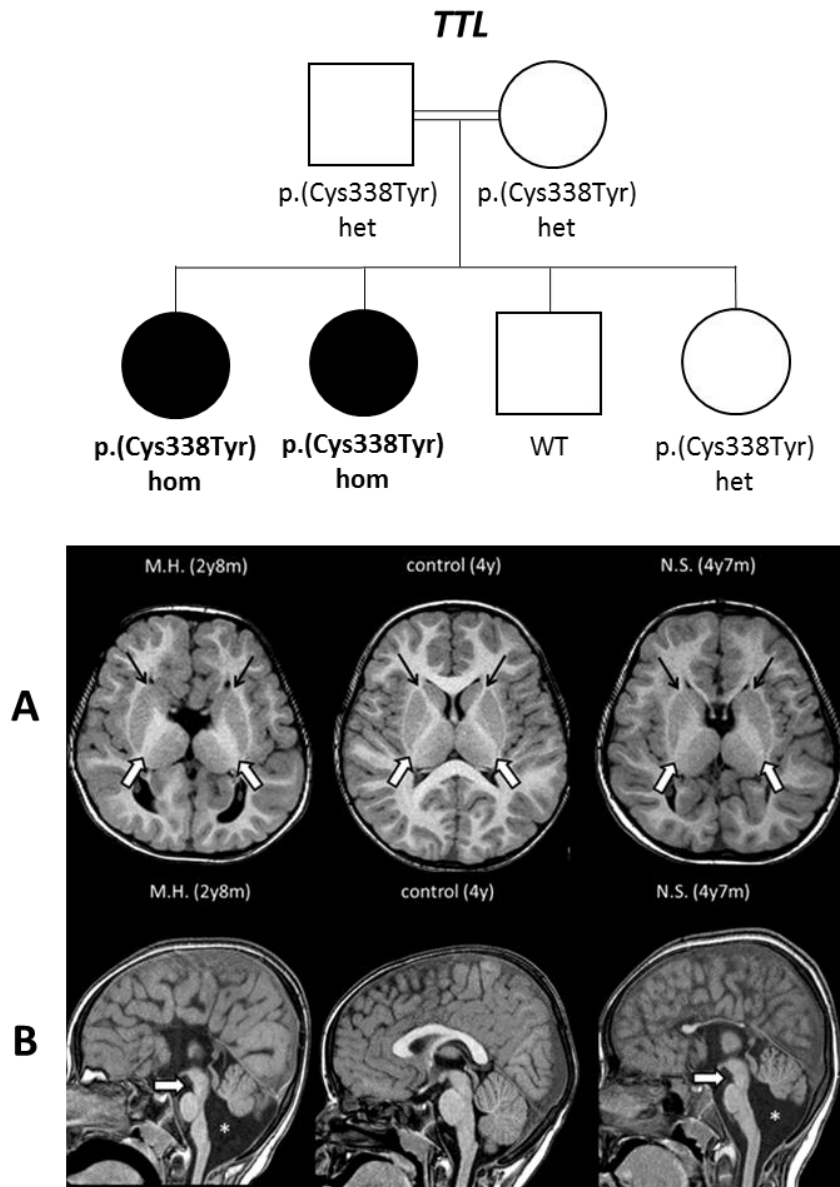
From the top: segregation analysis of the *TTL* variant; MR images of the two affected siblings versus a control showing Dysmorphic basal ganglia (upper black and white arrows) (A); hypoplasia of the cerebellar vermis and corpus callosum, enlarged cisterna magna (*), brainstem dysplasia (lower white arrows) (B);
